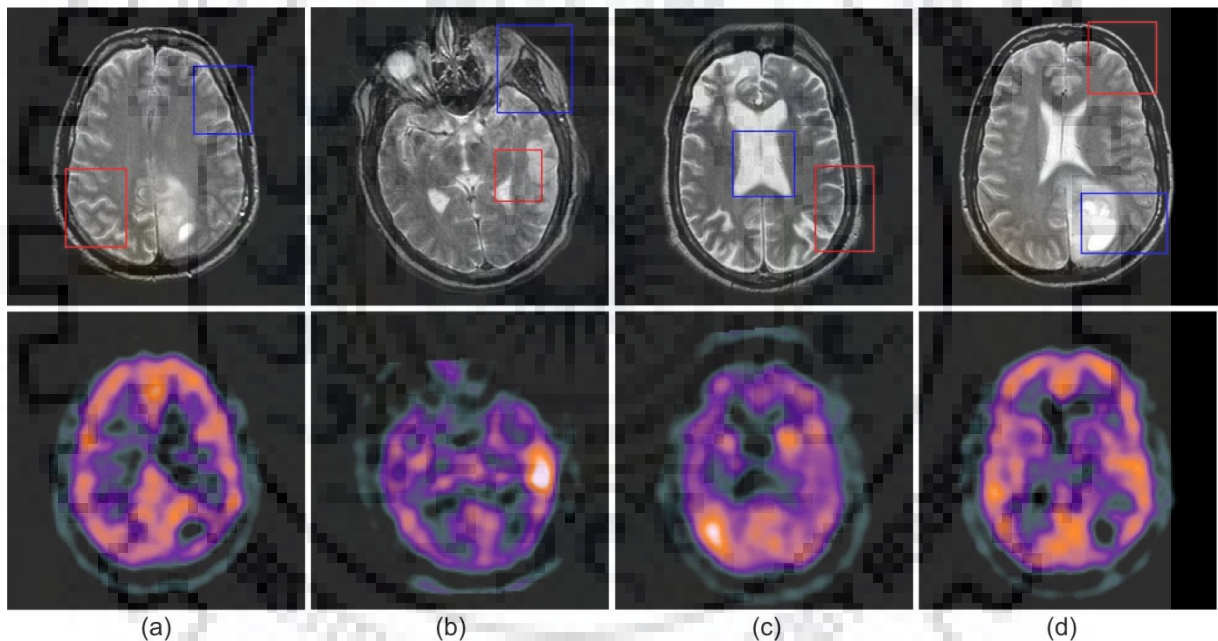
Source MR-SPECT image data (a) Pair 1 (b) Pair 2 (c) Pair (3) (d) Pair 4 with two marked regions by red and blue for showing the comparative analysis of fusion performance
